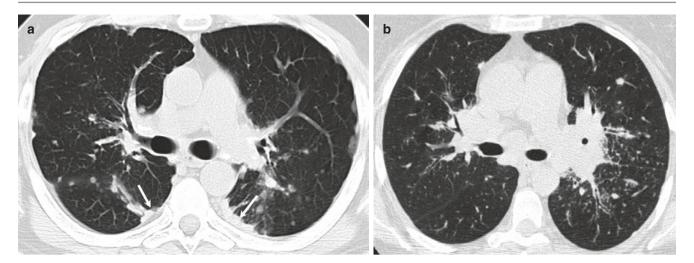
Sarcoidosis with perilymphatic nodules. (a) Axial CT image in a patient shows perilymphatic nodules in subpleural region and fissures with subpleural "pseudoplaque" formation posteriorly (arrows).
